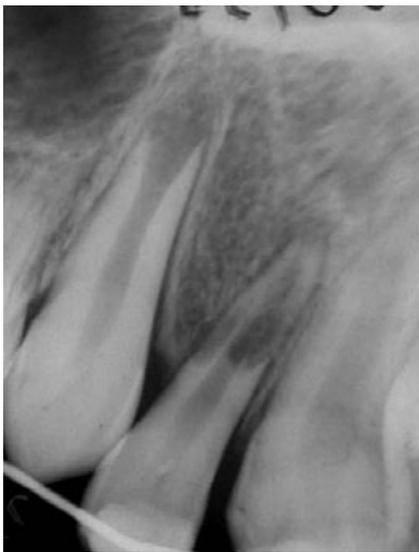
Radiograph taken on November 11, 1990, external root resorption.
